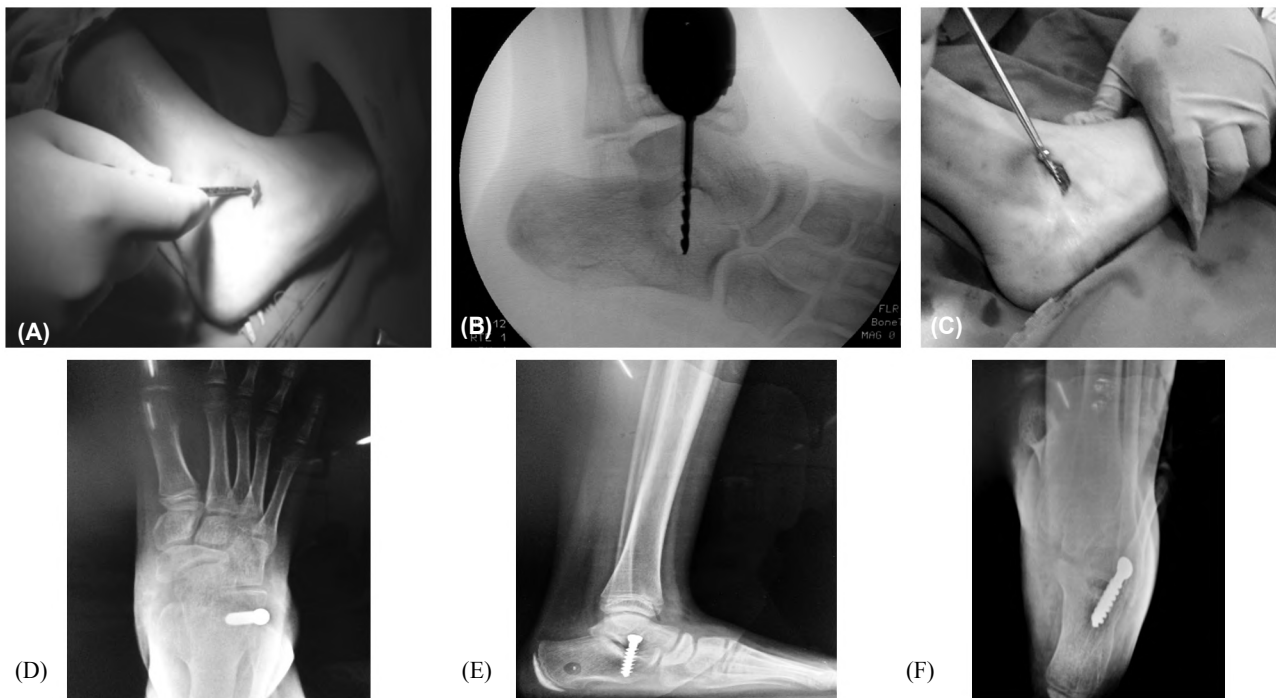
(A) Skin incision and blunt dissection, (B) Pre-drilling of the screw trajectory, (C) Screw insertion and advancement, (D,E,F) Postoperative radiographs.
